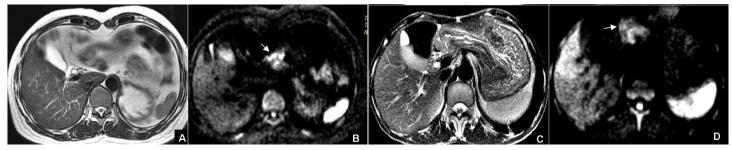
A, FRFSE T2WI, the cancer was blurred because of gastric peristalsis, which was overcame by DWI and displayed high signal (Fig 2B, white arrow). Fig 2C, SSFSE T2WI, the tumor border was not clear; Fig 2D, same case as Fig 2C, the cancer appeared high signal on DWI (white arrow).
